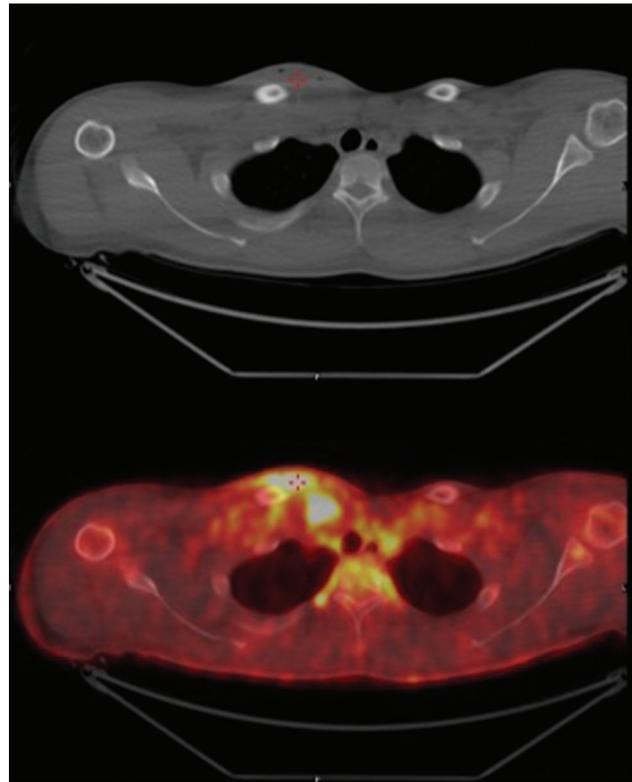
FDG-PET/TC scans of a case with Ewing sarcoma of the left clavicle before chemotherapy (t0).
